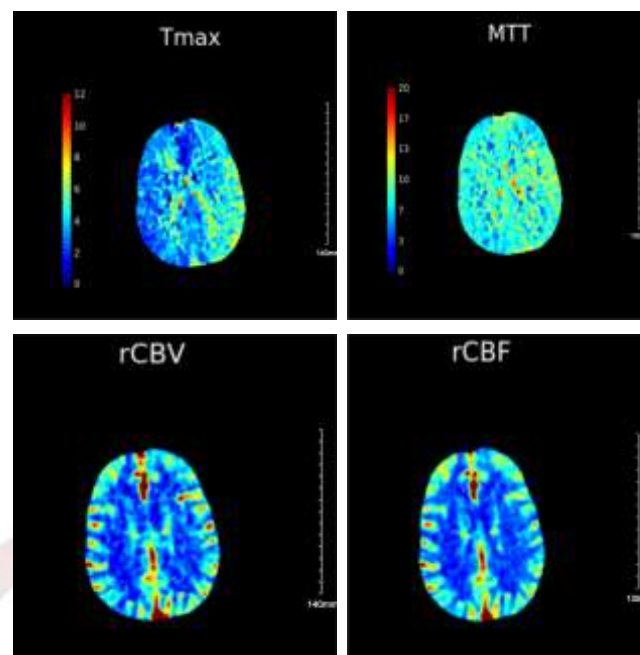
CT perfusion images showed prolonged Tmax and MTT in the contralateral side with normal rCBF and rCBV suggesting venous congestion. The right cerebral hemisphere showed normal CT perfusion imaging appearance.
